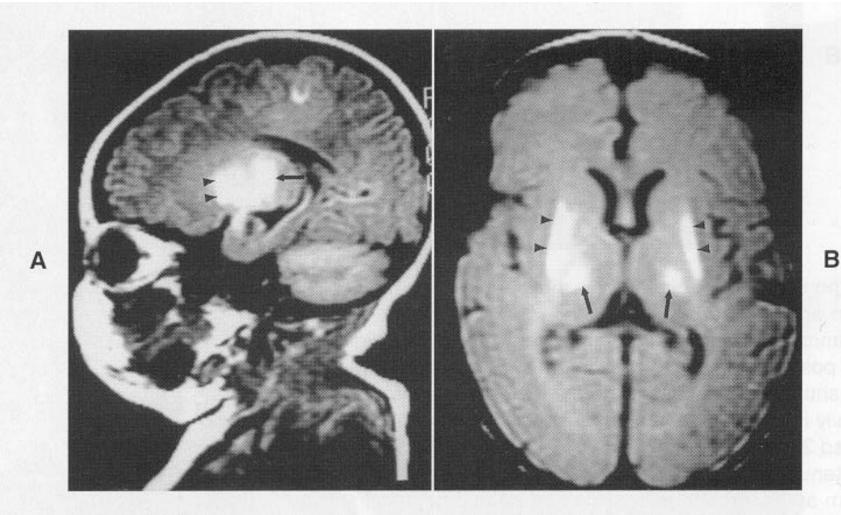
MRI scans of hypoxic-ischemic injury to basal ganglia and thalamus. Scans obtained from a 5-day-old infant who experienced severe perinatal asphyxia. A, Note in the parasagittal T1-weighted image markedly increased signal in basal ganglia, especially putamen (arrowheads), and in thalamus (arrow). B, The axial proton density image also demonstrates the injury well in the same distribution. (Courtesy of Dr. Patrick Barnes.)
